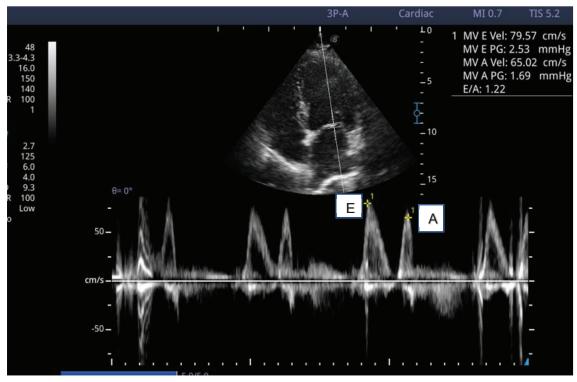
MV pulsed wave Doppler inflow pattern demonstrating the normal diastolic function
